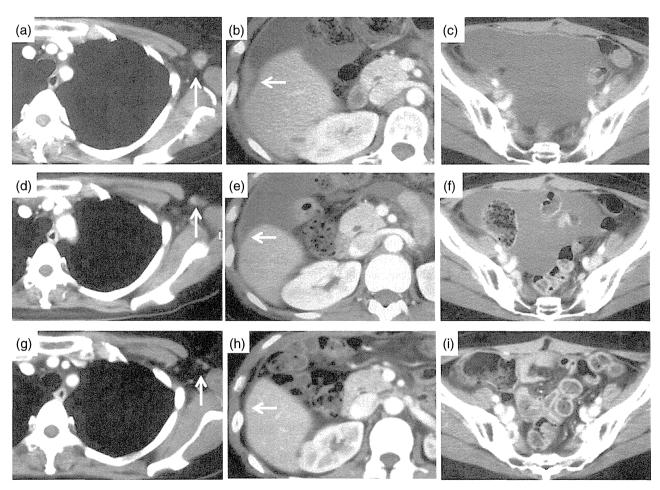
Computed tomography (CT) images of the patient with recurrent clear cell carcinoma of the ovary. CT images before combination therapy with bevacizumab, trabectedin and oxaliplatin showed (a) axillary lymph node metastasis, (b) intra-abdominal dissemination and (c) massive ascites. (d,e,f) Recurrent tumors showed partial response by CT images after 6 cycles of the therapy, and (g,h,i) achieved complete remission after 12 cycles of the therapy. Images a, d and g show left axillary lymph nodes (arrow), and images b, e and h show peritoneal disseminated tumor (arrow). Decrease of intraperitoneal ascites can be seen in images c, f and i.
